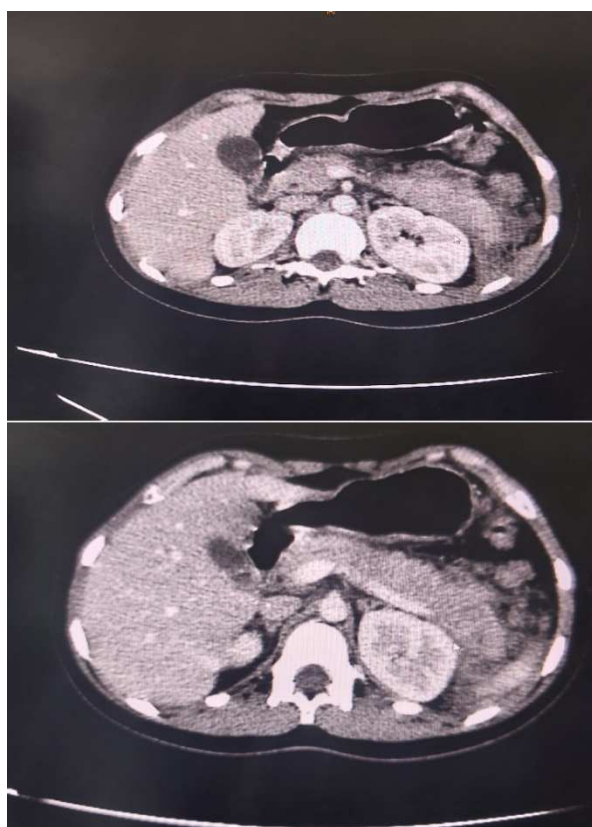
ABDOMINOPELVIAN CT scan: Aspect of acute pancreatitis classified as stage E according to BALHAZAR.
